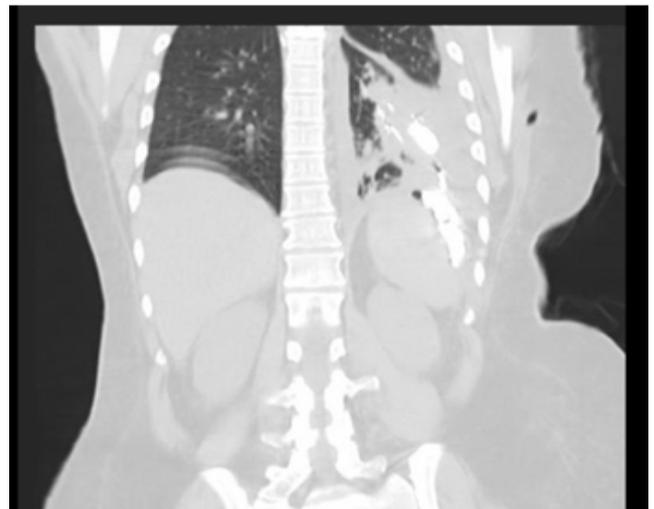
CT chest fistulous tract connecting subphrenic space to stomach and subphrenic space to left lung lower lobe.
